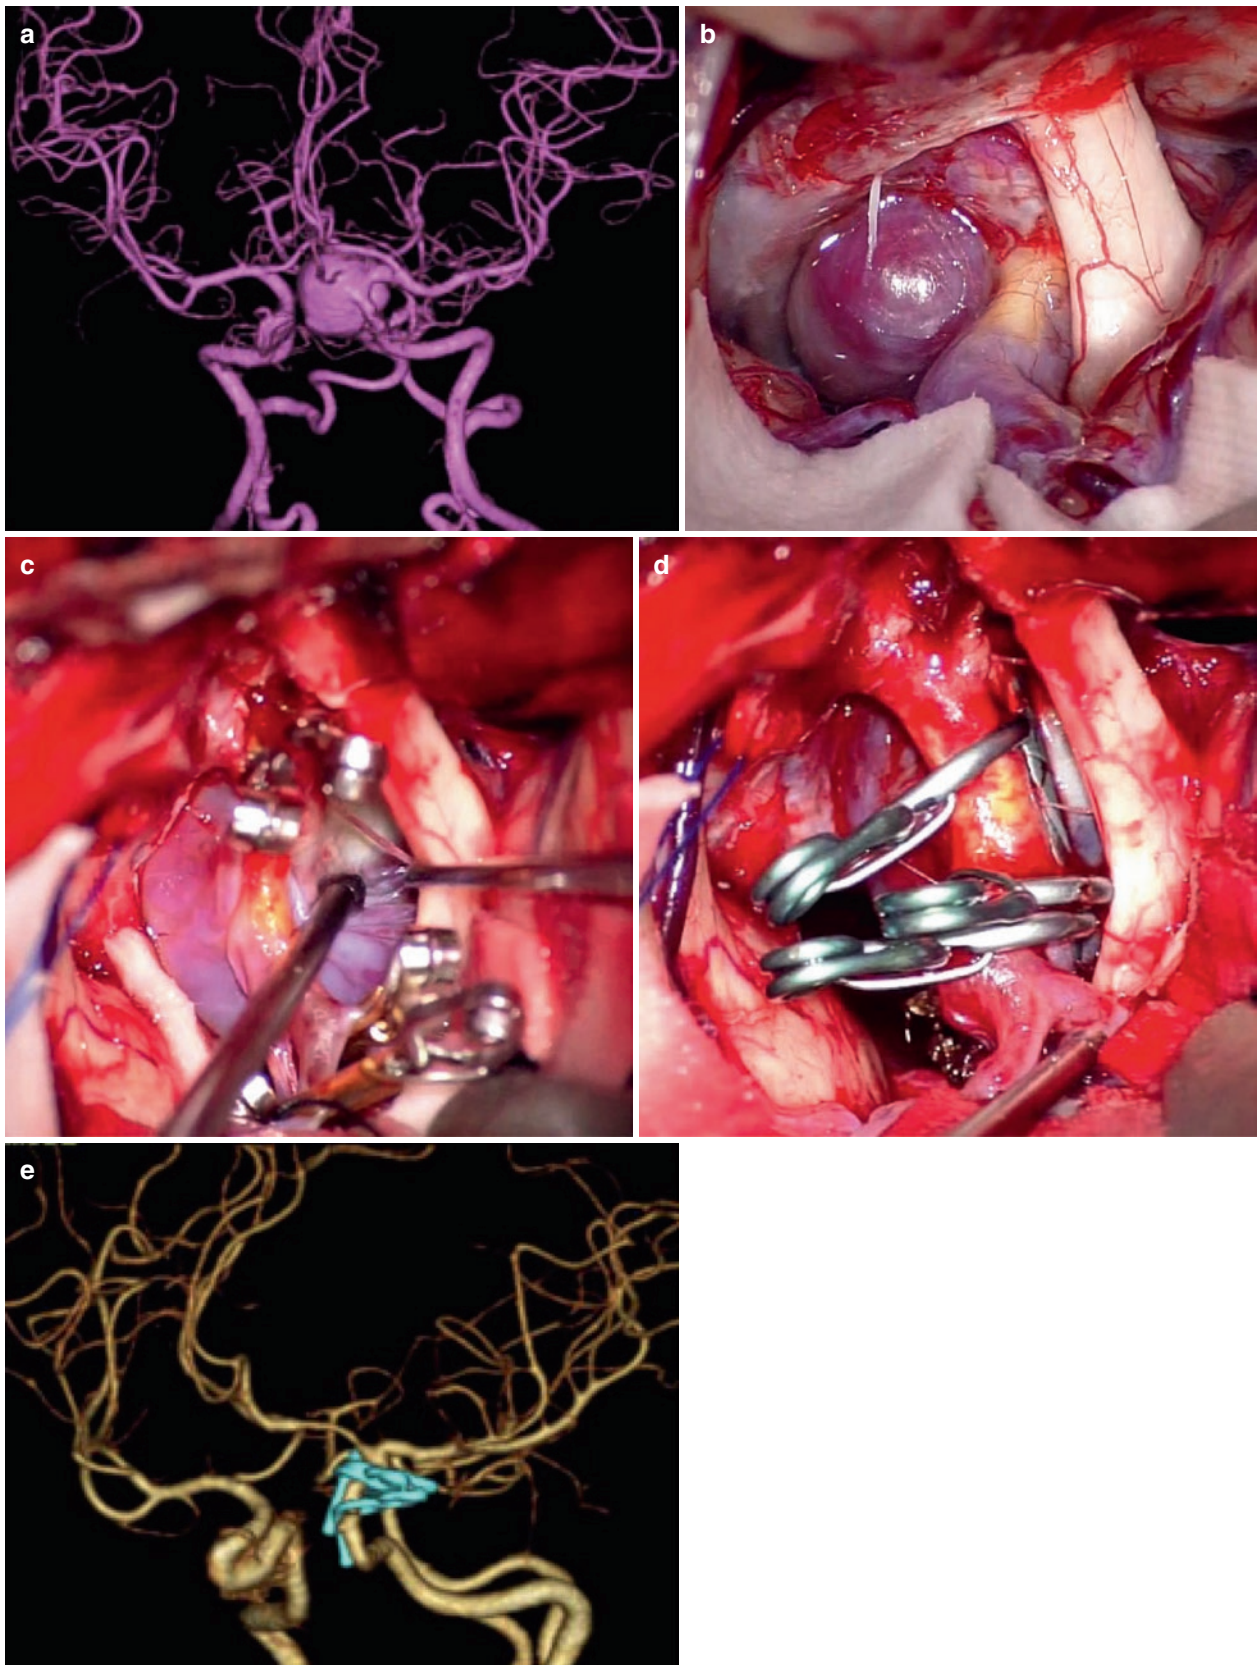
(a) 3D CTA demonstrating a large left IC-ophthalmic aneurysm. (b) An intraoperative photograph demonstrating an aneurysm and the left optic nerve through standard left pterional craniotomy. (c) The aneurysm was punctured, and suction decompression was performed.
